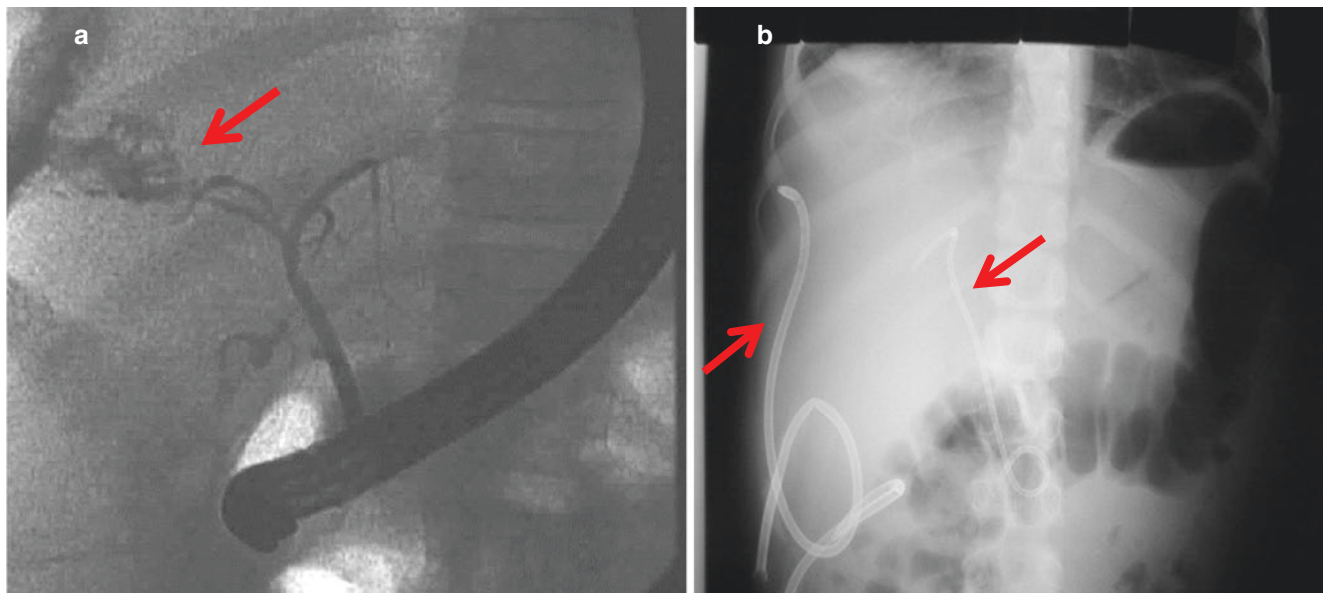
(a) ERCP contrast injection of the biliary tree reveals leakage of contrast form the laceration site in keeping with biliary leak. (b) Abdominal X-ray shows biliary drain in situ to decompress the biliary tree and intra-abdominal drain to drain intraperitoneal bile leak
